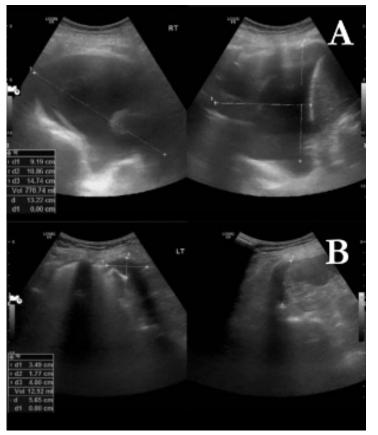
Chest ultrasound shows free fluid on the right (A) amounting to 771 mL and 13 mL on the left (B). At lectatic segments are seen in the right hemithorax
